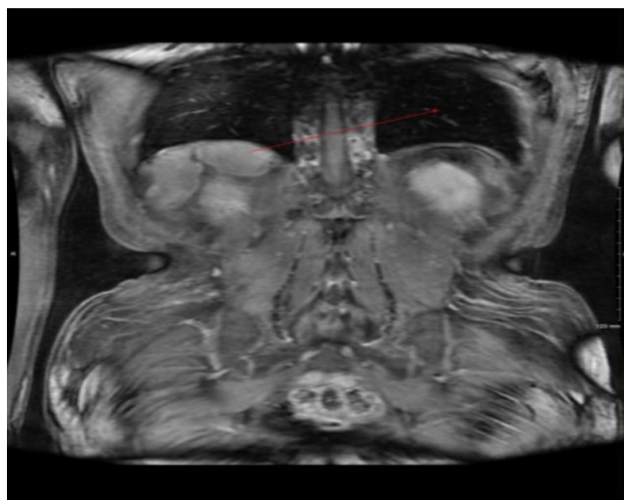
CT coronal section showing soft tissue nodules in the right posterior pararenal space suspicious for recurrent pheochromocytoma.
